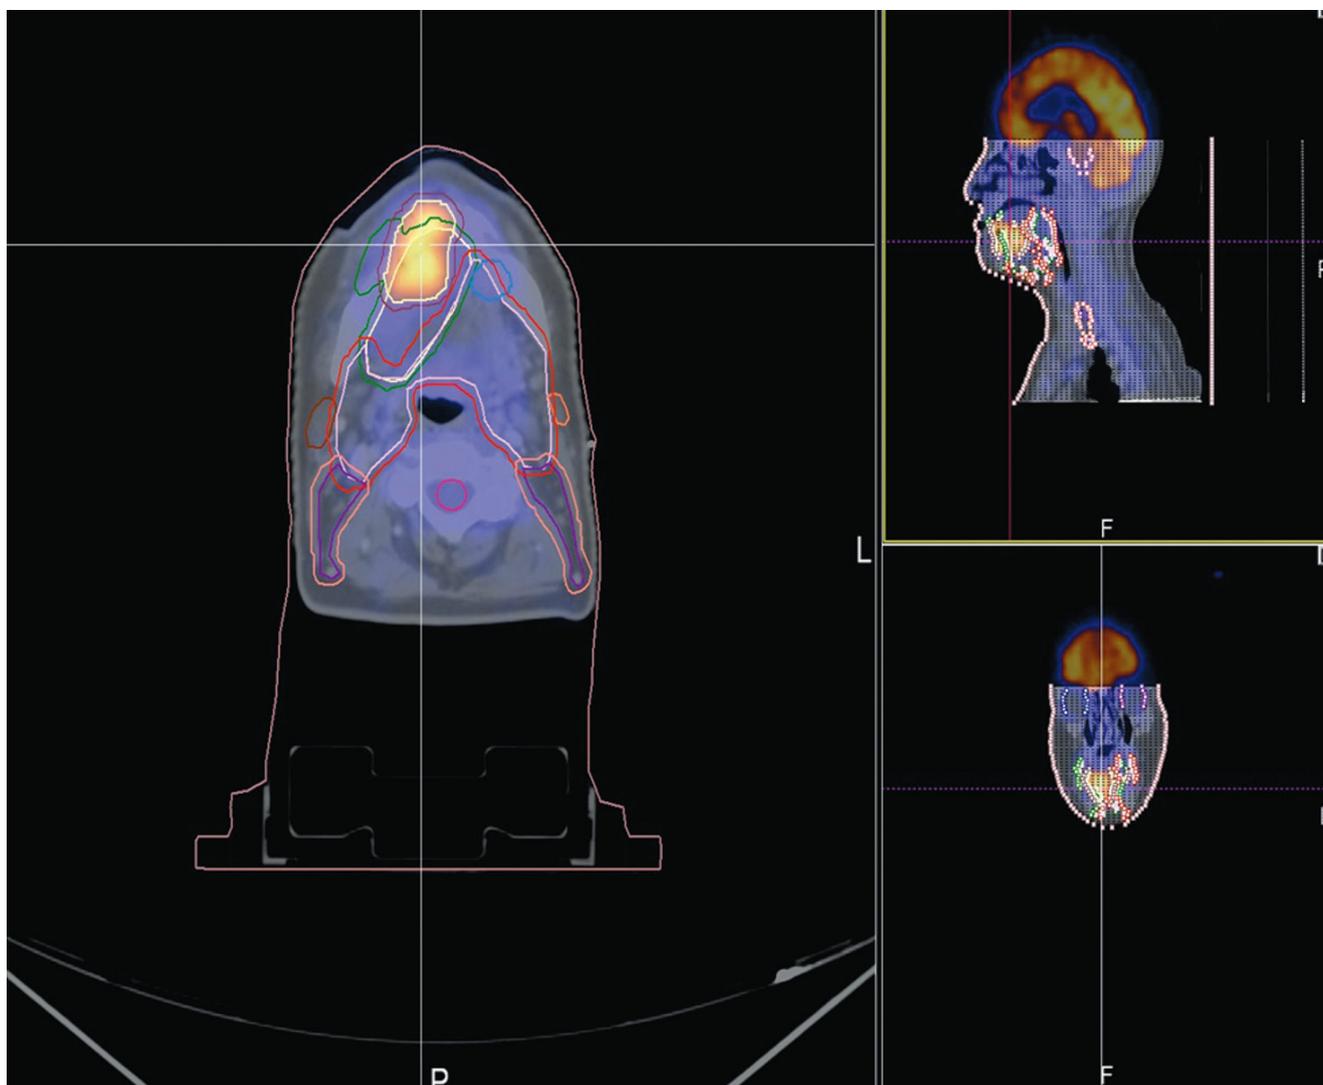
Delineation of radiation areas based on PET-CT
